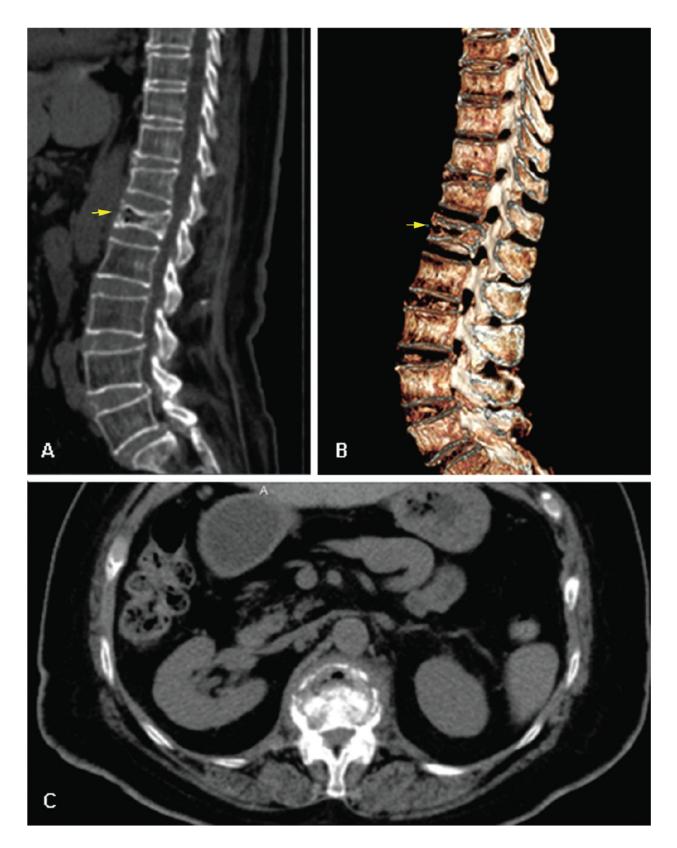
CT scan of the lumbar spine with compression fracture of L1 and intravertebral vacuum cleft (arrow). A Multiplanar reconstruction in sagittal, B volumetric reconstruction (3D), C axial plane.
